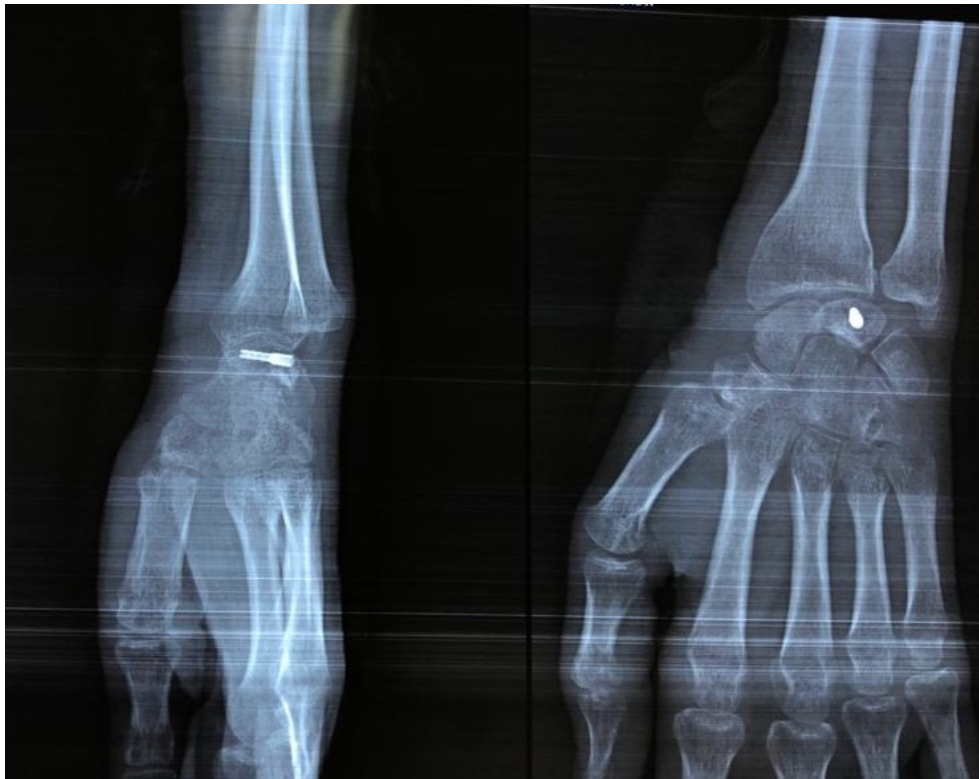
Standard radiographic after 6 months.
